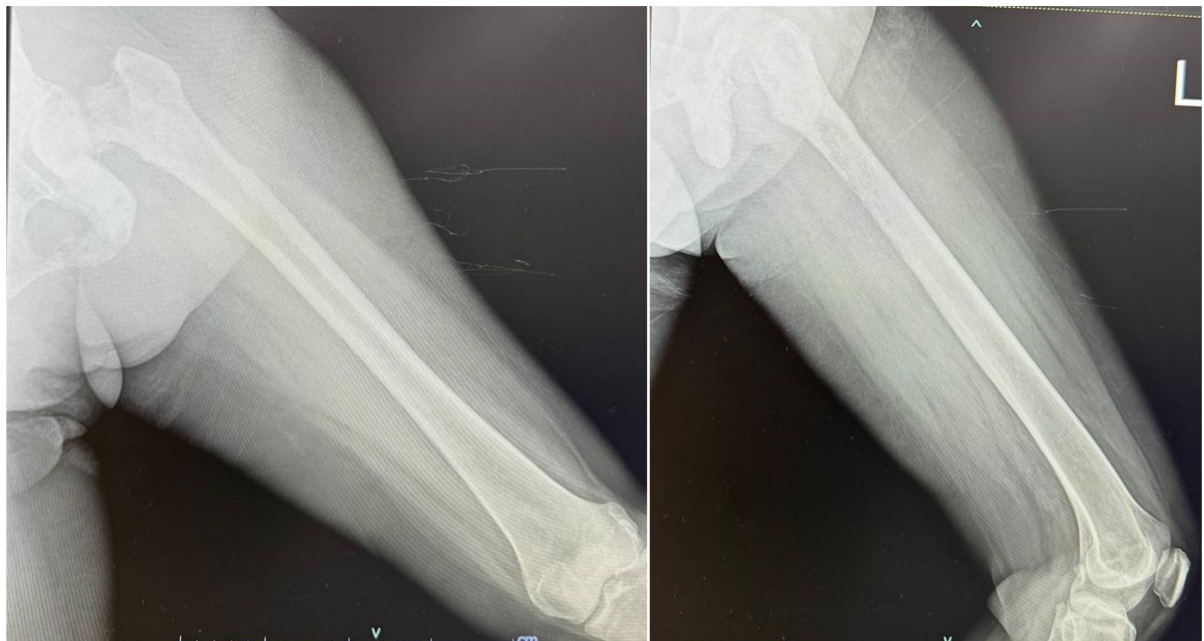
Thigh AP and lateral view X-rays noting on follow up noting pathologic fracture of the left femoral neck with lysis on the mid-distal aspect of the femur.
